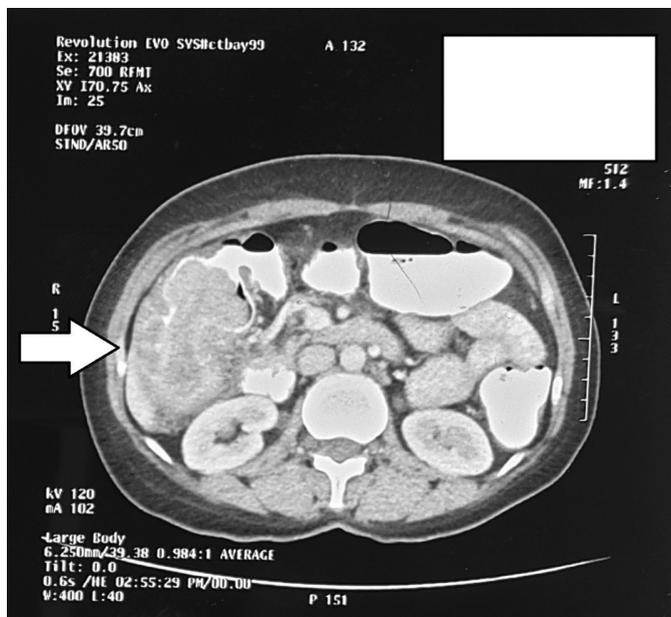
Contrast enhanced CT scan showing polypoidal right side colonic mass with colo-colic Intussusceptions
